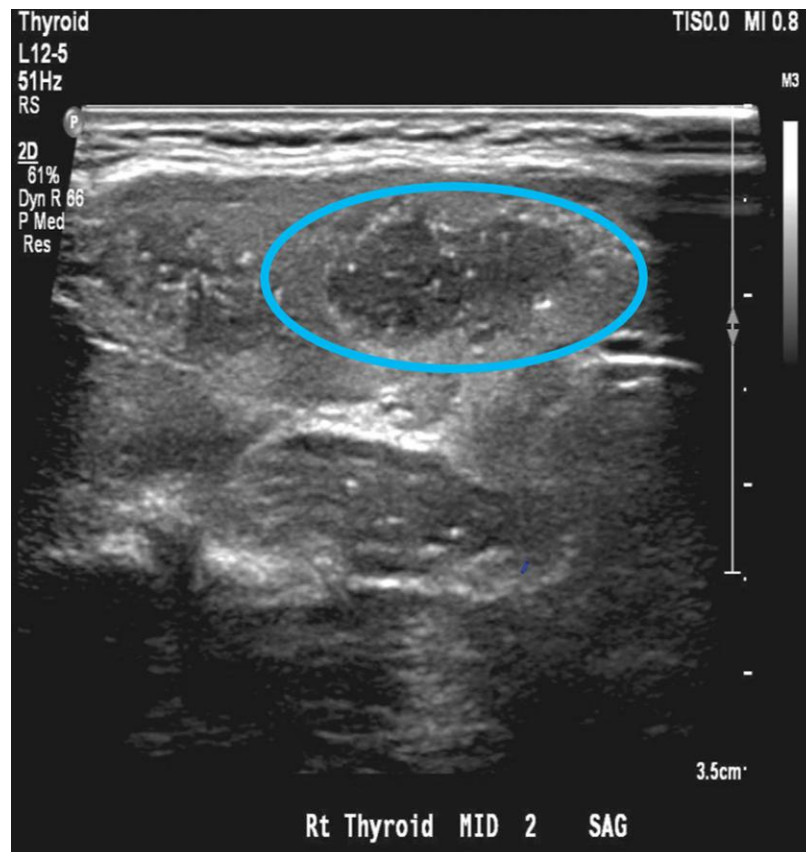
Ultrasound imaging shows a thyroid nodule with irregular borders and containing a myriad of tiny, brightly echogenic echogenic foci concerning for calcifications.
